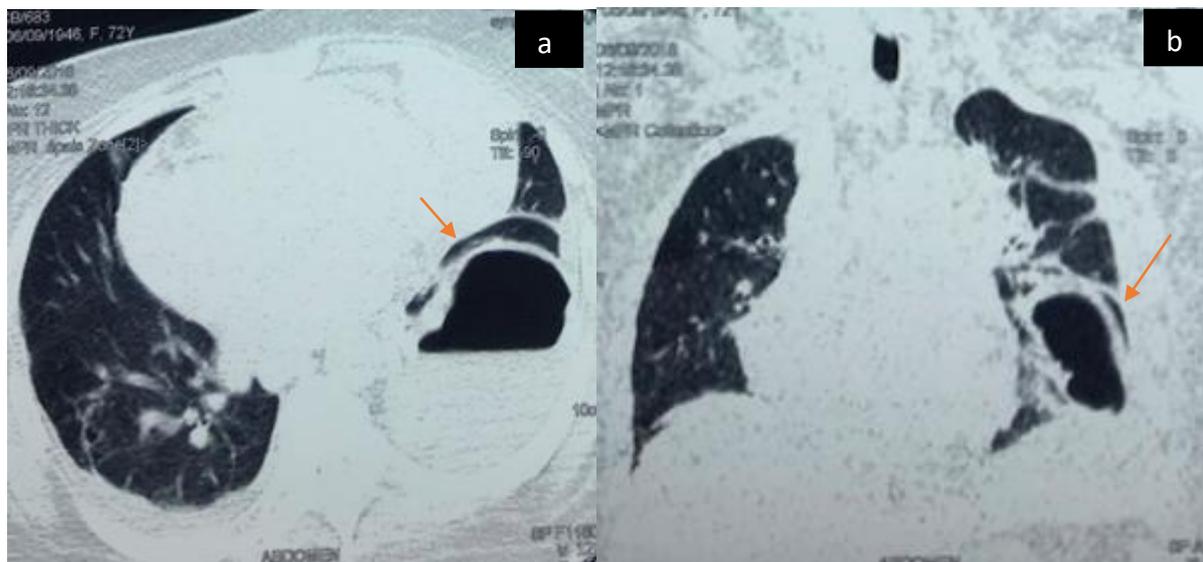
Axial (a) and coronal (b) planes of thoracic CT scan showing a huge pulmonary abscess.
